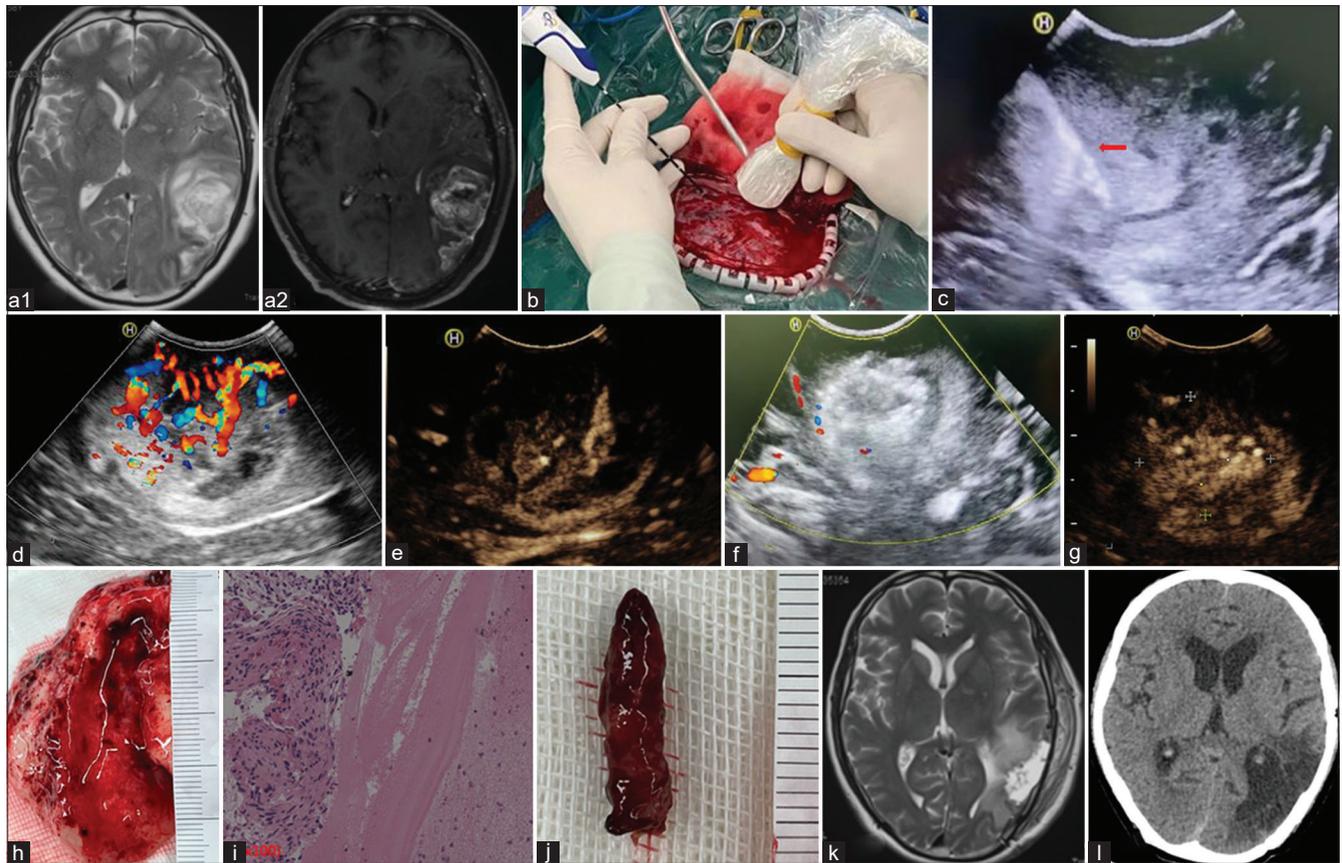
(a) A1 the axial T2-MRI indicated a lesion located in the left occipital-temporal regions, with a size of 4.8 cm × 5.2 cm; A2, the axial contrast-enhanced MRI showed abundant feeding artery, (b) the MWA treatment was carried out through a supraorbital craniotomy under the guidance of trans-operative ultrasound; (c) the MWA antenna (as indicated by red arrow) was inserted precisely into the lesions under the guidance of ultrasound, (d) abundant bloodstream signals branched into tumor on the color Doppler ultrasound; (e) CEUS images showed abundant bloodstream signals, (f) the color Doppler ultrasound showed blood flow signal was absent inside the tumor; (g) CEUS images showed an obvious non-perfusion area inside the tumor, (h) prominent central necrosis was observed in the postoperative glioma sample and was demarcated from surrounding tumor tissue; (i) a wide range of necrosis with distinct borders could be observed in the pathological section, (j) a tube-shaped carbonide was found in the postoperative glioma sample, (k) the axial T2-MRI showed that obvious edema in surrounding tissues of the operation area was observed 24h after the surgery; (l) the axial CT showed no local tumor recurrence at 7 months after the surgery
